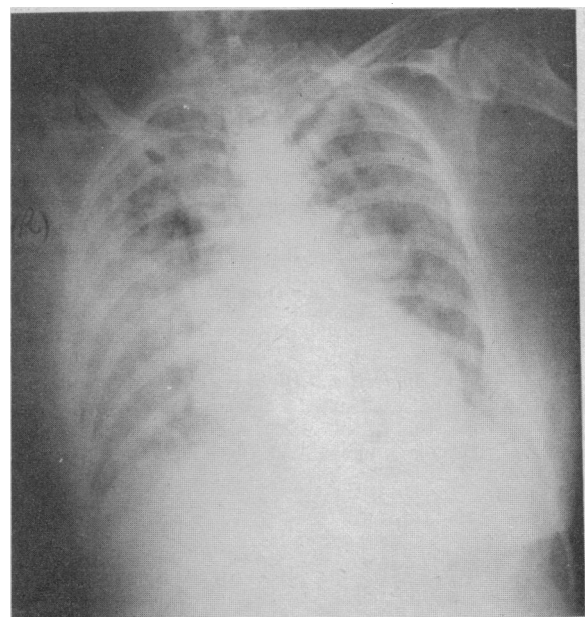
Case 3. Chest x-ray appearances 2½ hours after near-drowning incident.
